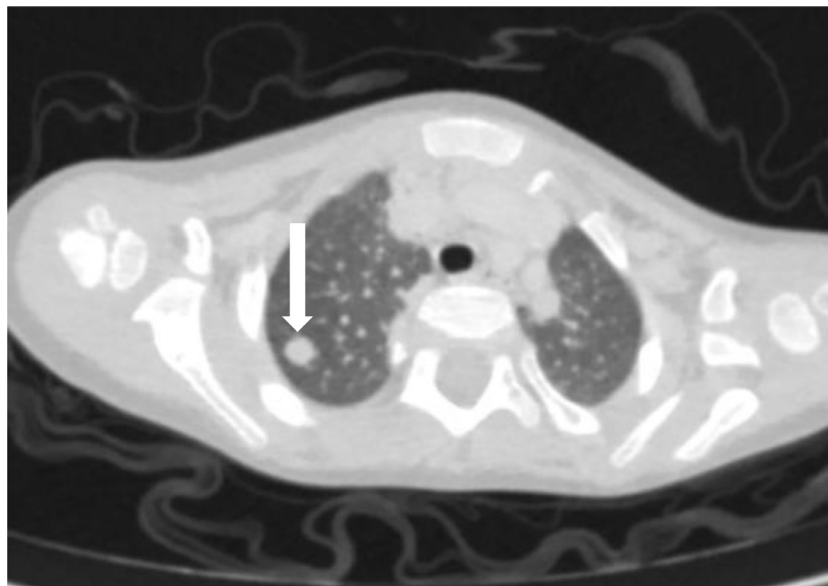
Axial CT section of lung window revealed a metastatic pulmonary nodule (white arrow).
